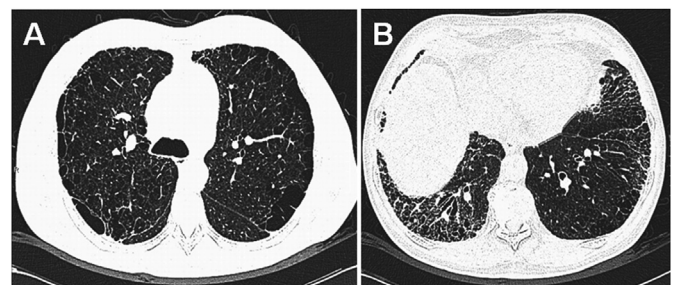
Combined pulmonary fibrosis and emphysema (CPFE). Panel A: High-resolution computed tomography showing emphysematous areas in upper lobes. Panel B: Extensive subpleural fibrosis and bronchiectasis in the lower lobes of the same patient.
